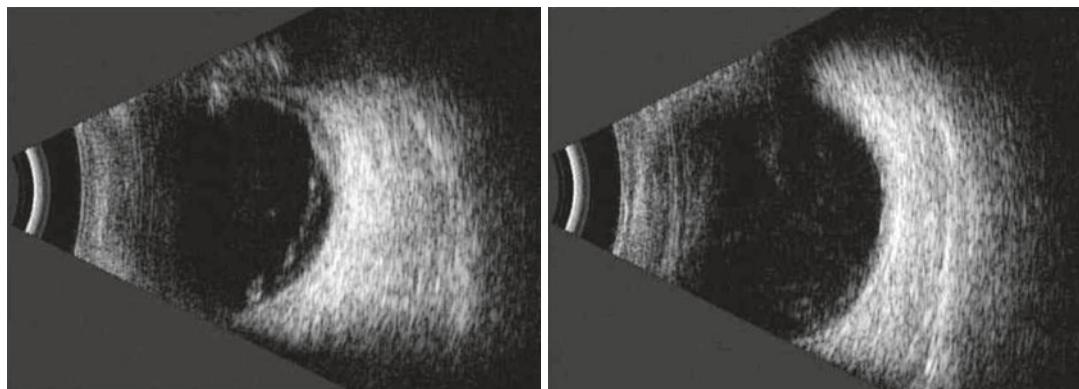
B ultrasound demonstrated vitreous opacity and segmental choroidal detachment (left). On follow-up at 35 days, both of them improved (right)
